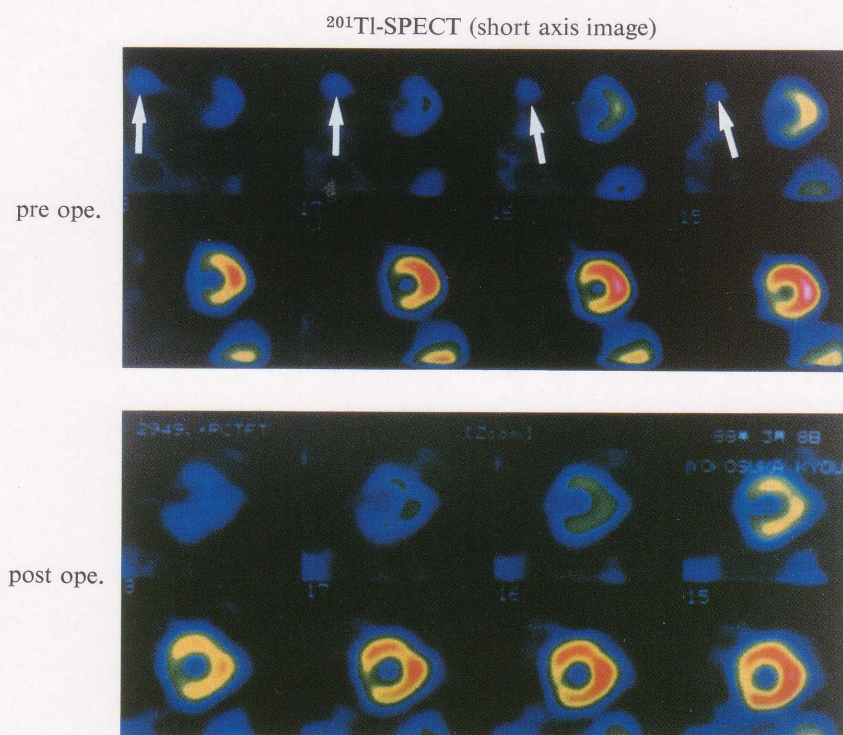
Short axis image of thallium-201 SPECT. Abnormal thallium-201 uptake by the tumor (arrows) was seen before the operation, but not after.
